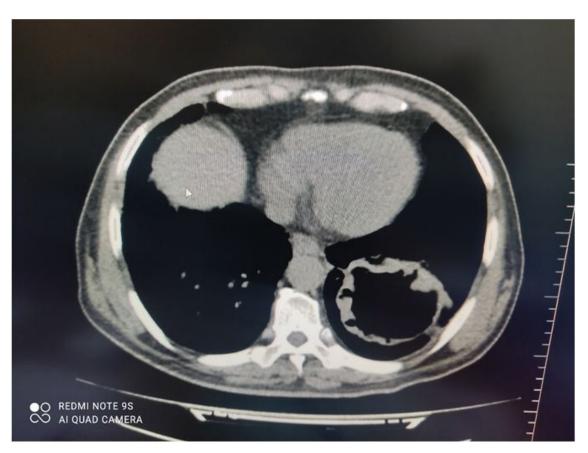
A hypodense subcarinal lymph node was observed in axial Thorax CT image
